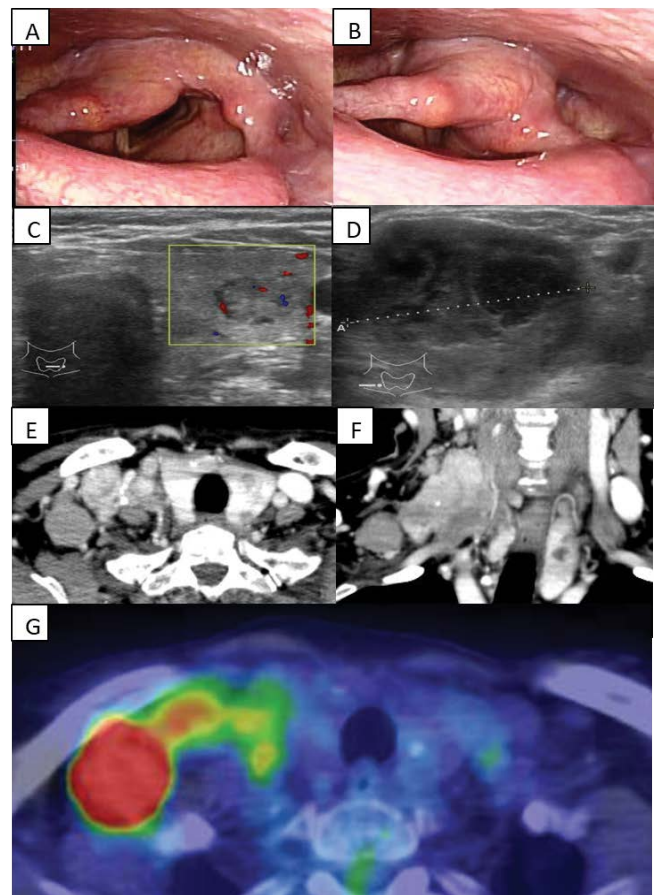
Endoscopic, cervical ultrasonographic, computed tomography, and positron emission tomography findings.
